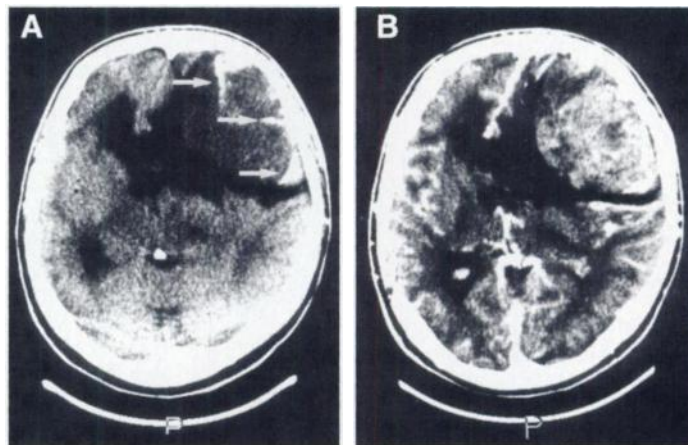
(A) Plain and (B) intravenous contrast enhancement brain CT images. Plain CT image demonstrates curvilinear calcification at the periphery of the tumor (white arrows). Contrast-enhanced image shows inhomogeneous enhancement with less enhanced areas in the center, anterior and medial portions.
